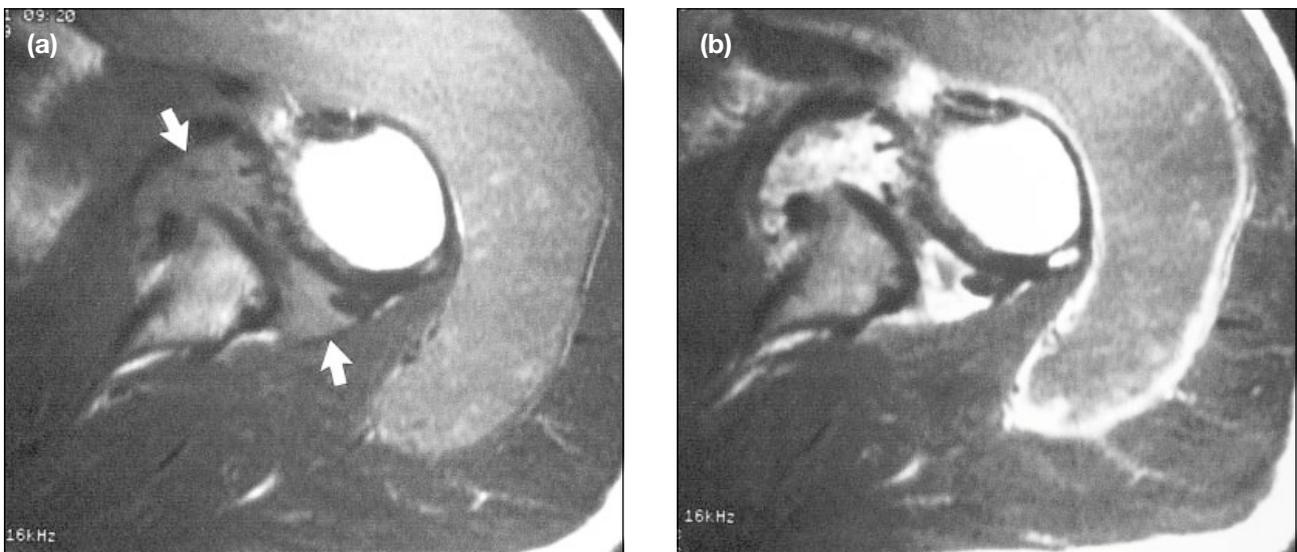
Elderly patient with longstanding rheumatoid arthritis and progressive shoulder swelling. Transverse T1-weighted images of the shoulder (TR 400 ms/TE 19 ms). On precontrast images (a), distension of the glenohumeral joint, with bulging of the anterior and posterior recesses of the capsule, can be discerned (arrows). In addition, a large area of slightly increased signal intensity is noted anteriorly and laterally, representing a grossly distended subacromial subdeltoid bursa. Note numerous small rice bodies outlined by the effusion. On postcontrast images (b), the glenohumeral joint shows pronounced enhancement, with only a few tiny pockets of non-enhancing synovial fluid. In this instance, almost the entire volume of the joint represents pannus. On the other hand, the subacromial subdeltoid bursa is filled predominantly with a large quantity of synovial fluid, although some thickening and nodularity of the synovial membrane, particularly posteriorly, can be discerned.
